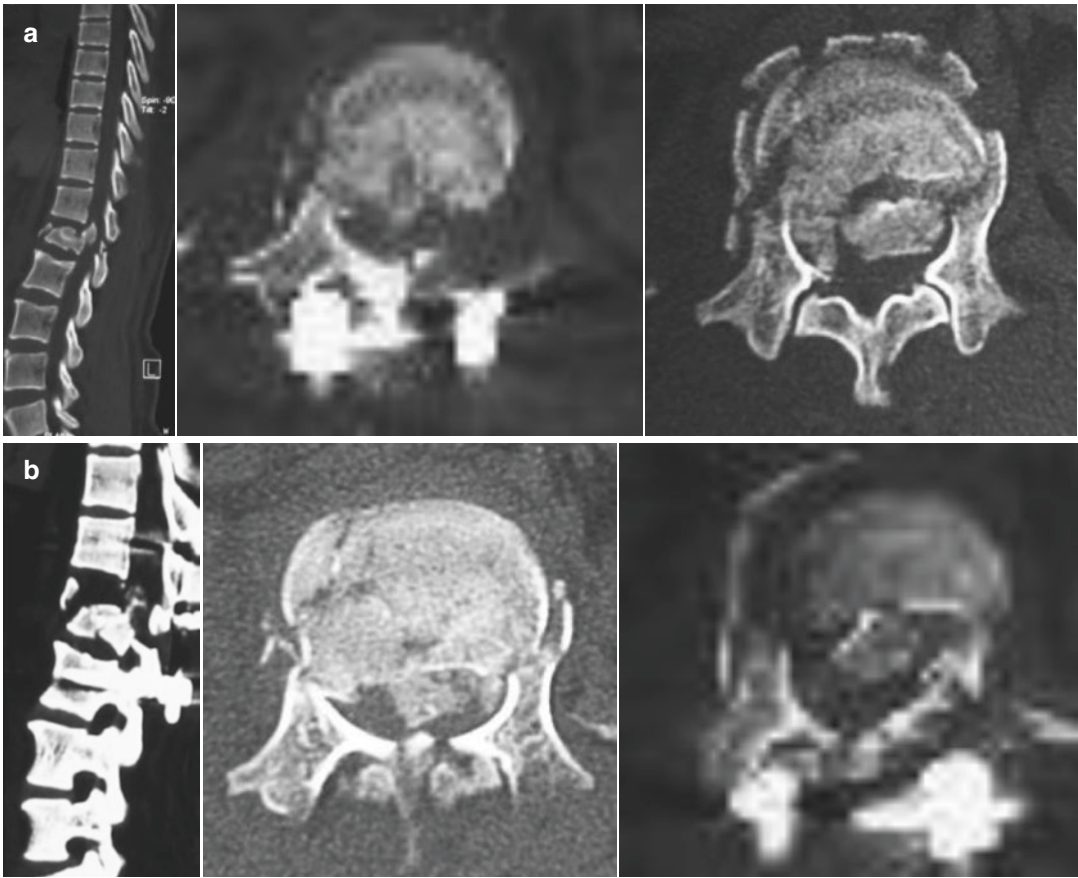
(a) 40-year old patient . CT control after the first stage of surgical treatment: spondylodesis, transpedicular 4-screw fixation of L1 fracture at the Th12–L2 level. (b) The same patient. The second stage of surgical treatment. in 10 days and CT control
